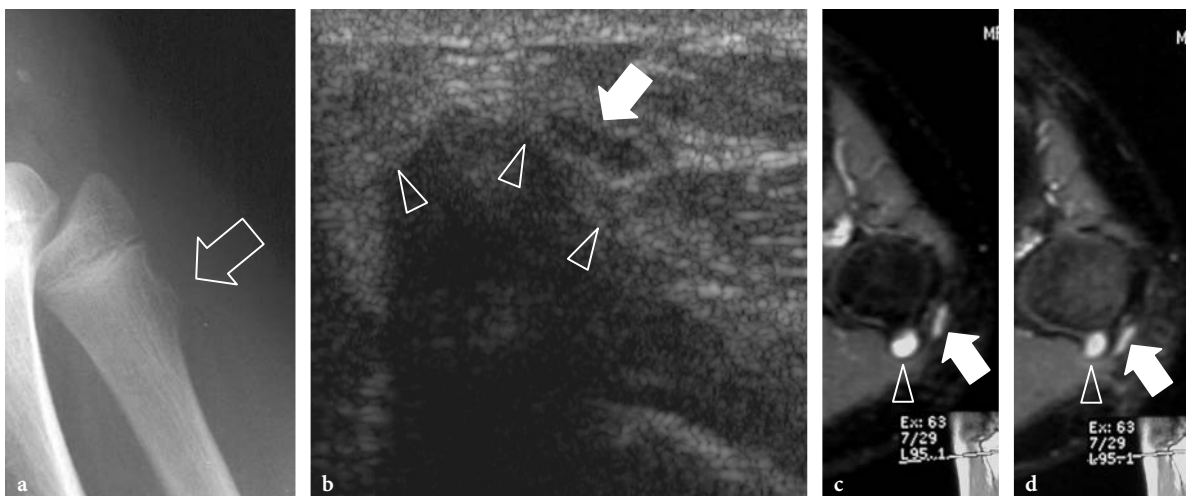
Nerve contusion trauma. Peroneal neuropathy in a 15-year-old boy with onset of foot-drop after receiving a blow on the lateral knee. a Lateral plain film demonstrates an exostosis (*arrow*) at the fibular metaphysis. b Transverse 12–5 MHz US image reveals impingement of the peroneal nerve (*arrow*) against the cartilaginous component (*arrowheads*) of the exostosis. The nerve is swollen and hypoechoic. c,d Correlative transverse fat-suppressed GRE T2* MR images demonstrate a hyperintense nerve (*arrow*) crossing the exostosis (*arrowhead*). Note the T2-hyperintense cap of the exostosis
